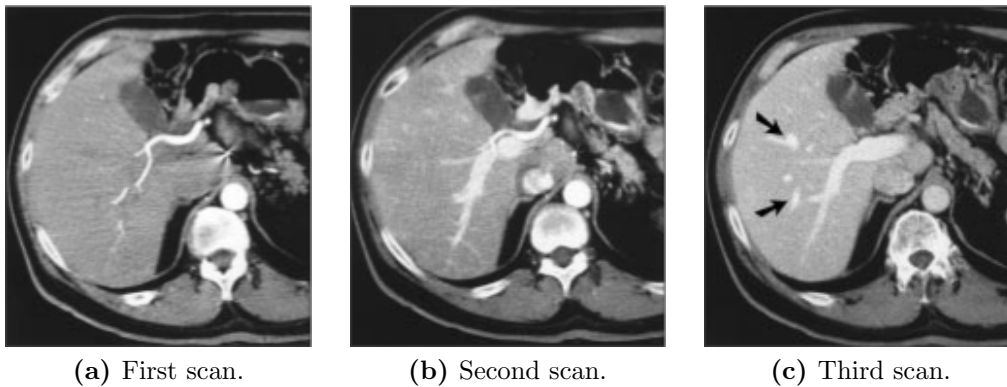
Examples of multiple scans for hepatic *CT*. As the blood flow in the liver vessels is relatively slow, multiple *CT* scans can be used in order to segment the vasculature. The images (a), (b), and (c) show the contrast medium at different points in time and are taken from [11].
